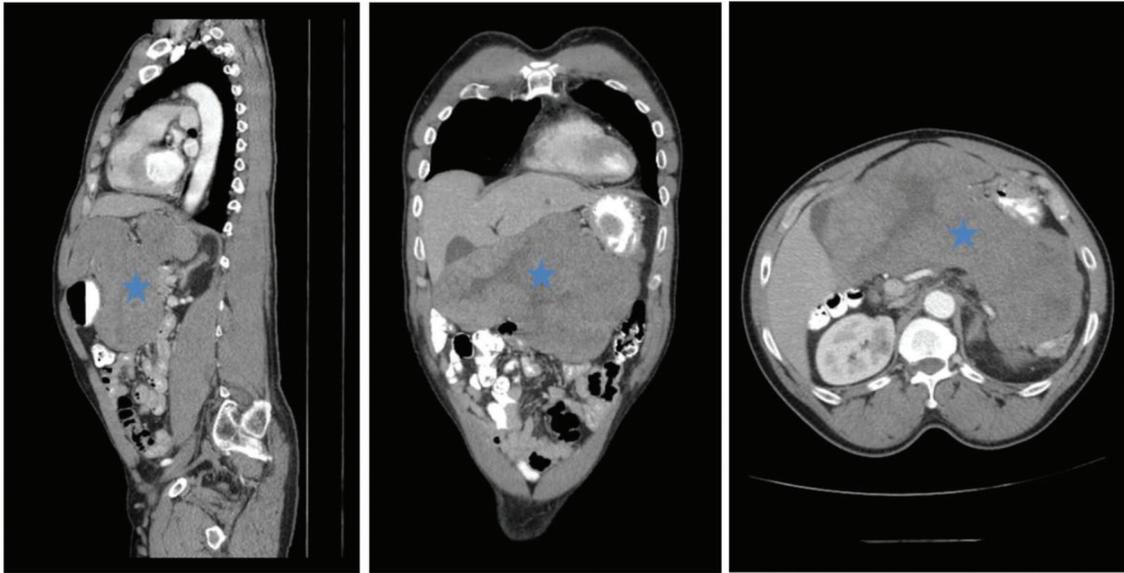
CT scan abdomen/pelvis with contrast showing large soft tissue density mass inseparable from the lesser curvature of the stomach marked with asterisk.
